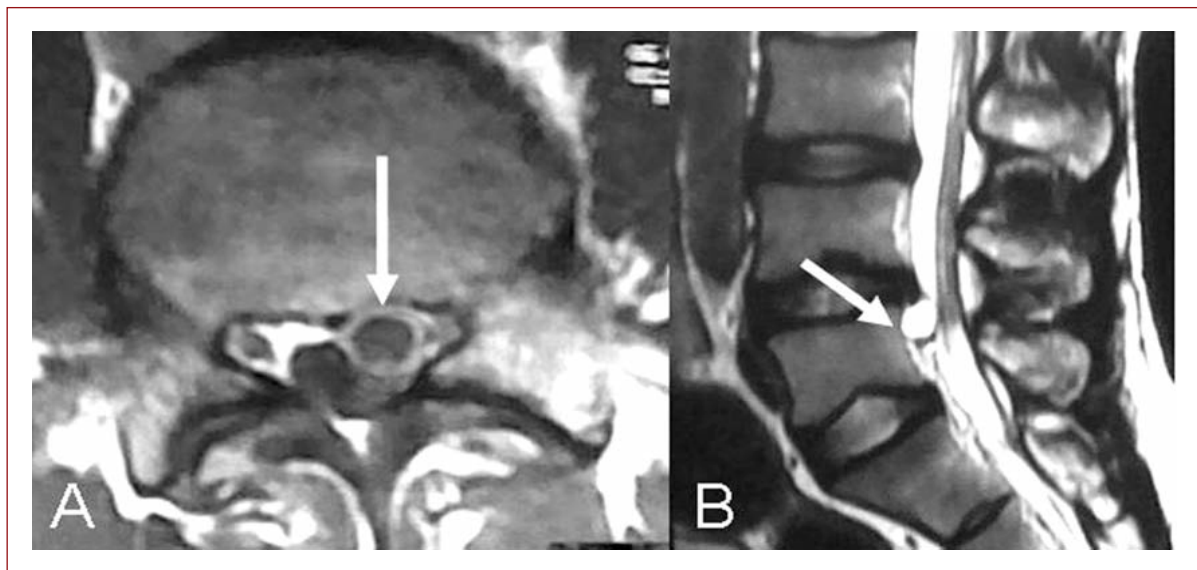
Preoperative MRI of lumbosacral spine. a. Axial T1W image showing perineural cyst (marked with an arrow). b. Sagittal T2W image showing the perineural cyst (marked with an arrow).
